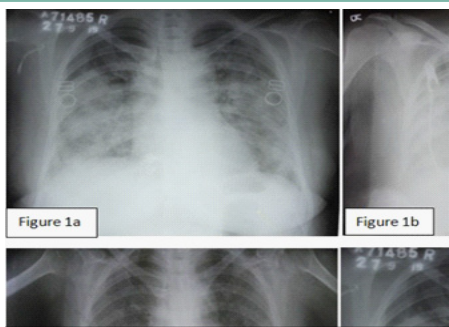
Chest X-ray of the patient depicting the clinical course. (1a) Bilateral inhomogeneous opacity at the time of admission. (1b): Increase in opacities with involvement of upper zones on next day. (1c) Resolution of opacities on starting treatment. (1d) Reappearance of bilateral inhomogeneous opacities at the time of R-LON.
